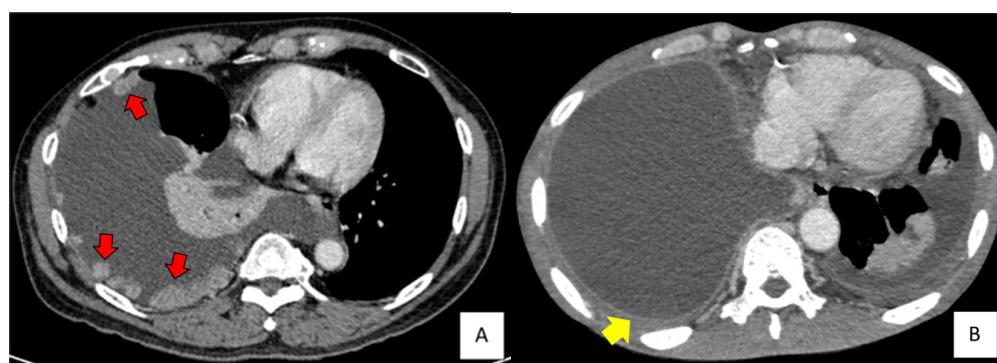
Standard reconstruction chest CT images show multiple enhanced pleural nodules (red arrows) (A) and extrapleural fat clouding (yellow arrow) (B).
